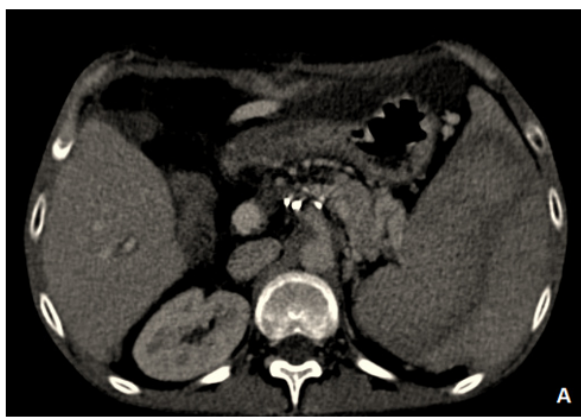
Axial CT section with contrast enhancement at portal phase shows a delayed and inhomogeneous enhancement realizing a geographic aspect of the spleen.
